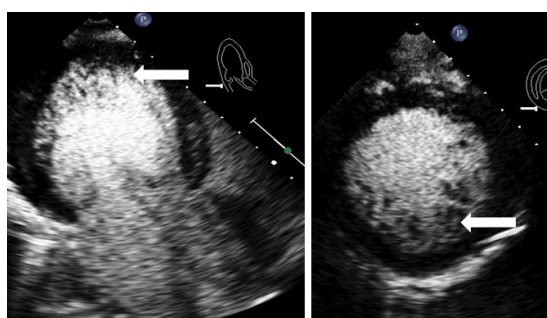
2D echocardiogram with perflutren lipid microsphere echo contrast (DEFINITY®) of the left ventricle in the apical three chamber and parasternal short axis view showing compacted and non-compacted myocardium (arrow)
